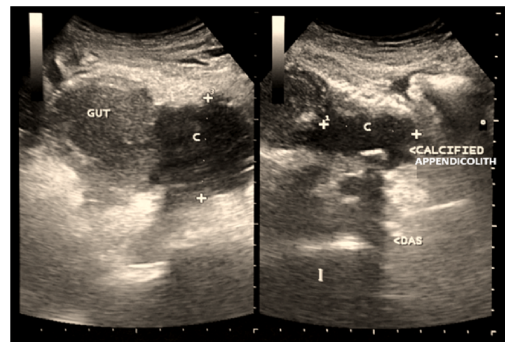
Sonographic Appearance as Seen in Case of Perforated Appendix. A loculated Hypoechoic Collection is Present in Relation to the Terminal Ileum and Caecum
